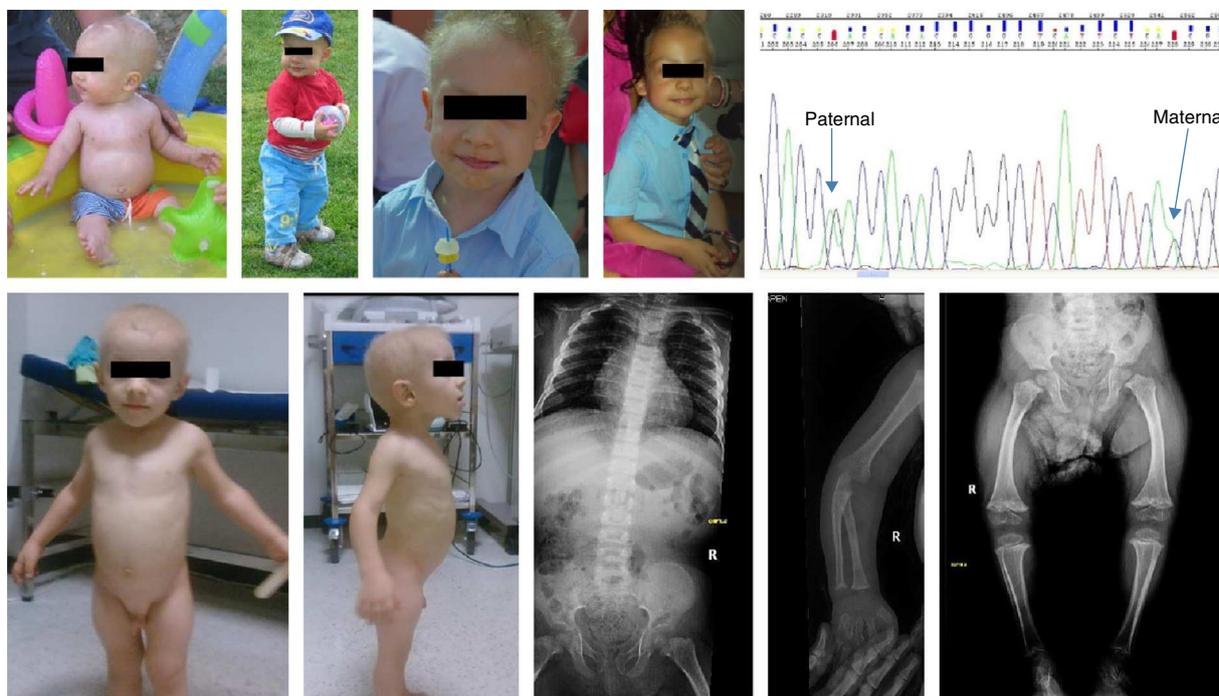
Top: case 1 patient at 9 and 18 months, and at 5 and 7 years, respectively. Mutations found in the *RMRP* gene. Bottom: case 2 patient at 4.5 years of age and radiographs at 2 years of age.
